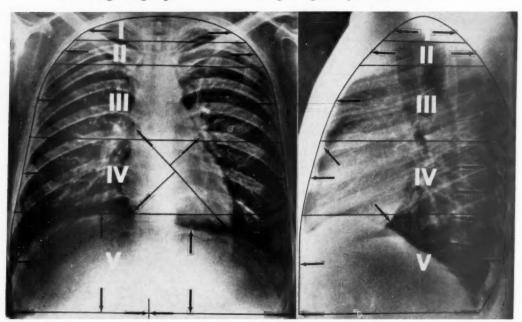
Roentgenograms prepared for measurement. The arrows indicate the actual points between which to measure.
